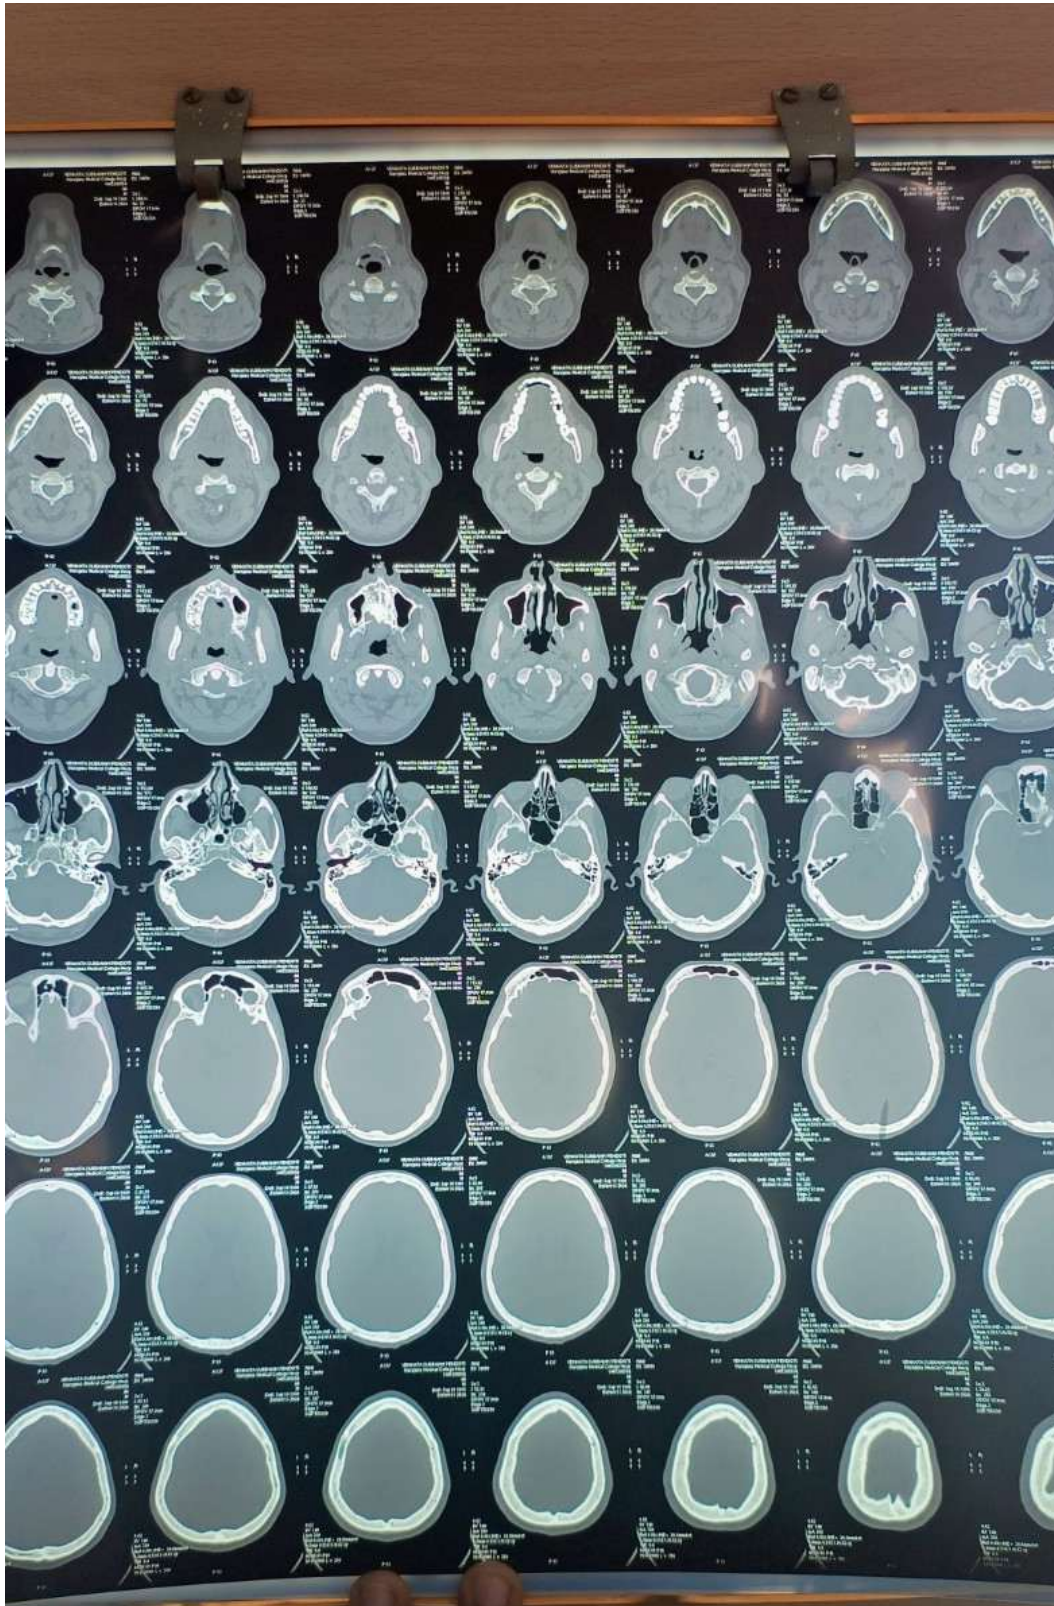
Axial CT images of the skull base demonstrating a destructive lesion involving the left sphenoid wing with extension toward the cavernous sinus and orbital apex, corresponding to the patient's presenting symptom of diplopia.
